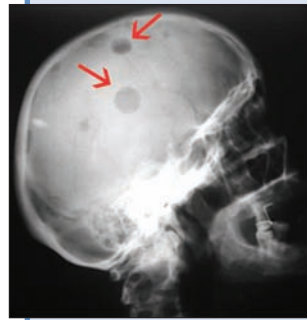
Radiograph of the lateral skull showing radiolucent bony lesions (arrows).
